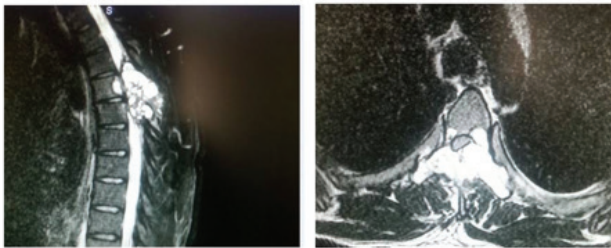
T2-weighted sagittal and axial magnetic resonance imaging T2-weighted image of the thoracic spine demonstrating a lytic lesion involving predominantly the posterior elements of the T5 and T6 vertebrae
